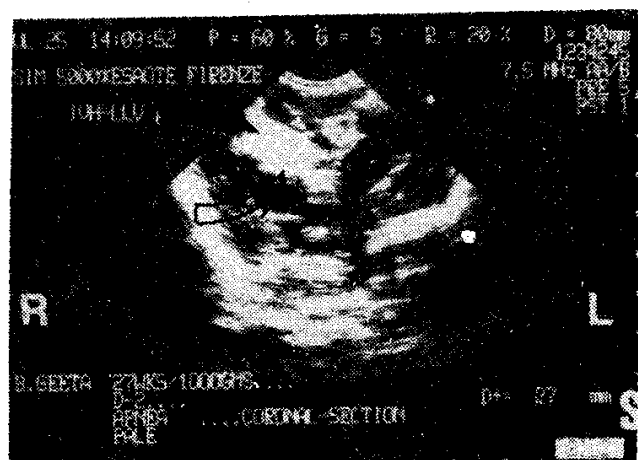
Coronal sonogram showing right sided IVH (open-arrow) with extension into the cortex (Grade IV) (arrow).
